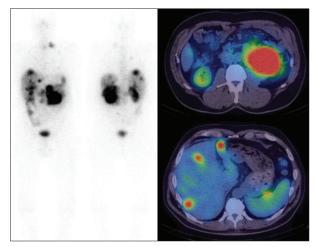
111In-DTPA-octreotide whole-body and single-photon emission computed tomography/computed tomography (SPECT/ CT) study in a patient with metastatic pancreatic neuroendocrine tumour. The whole-body study demonstrates uptake in the left supraclavicular fossa, liver, and abdomen. SPECT/CT images demonstrate pancreatic primary and liver and splenic metastases
